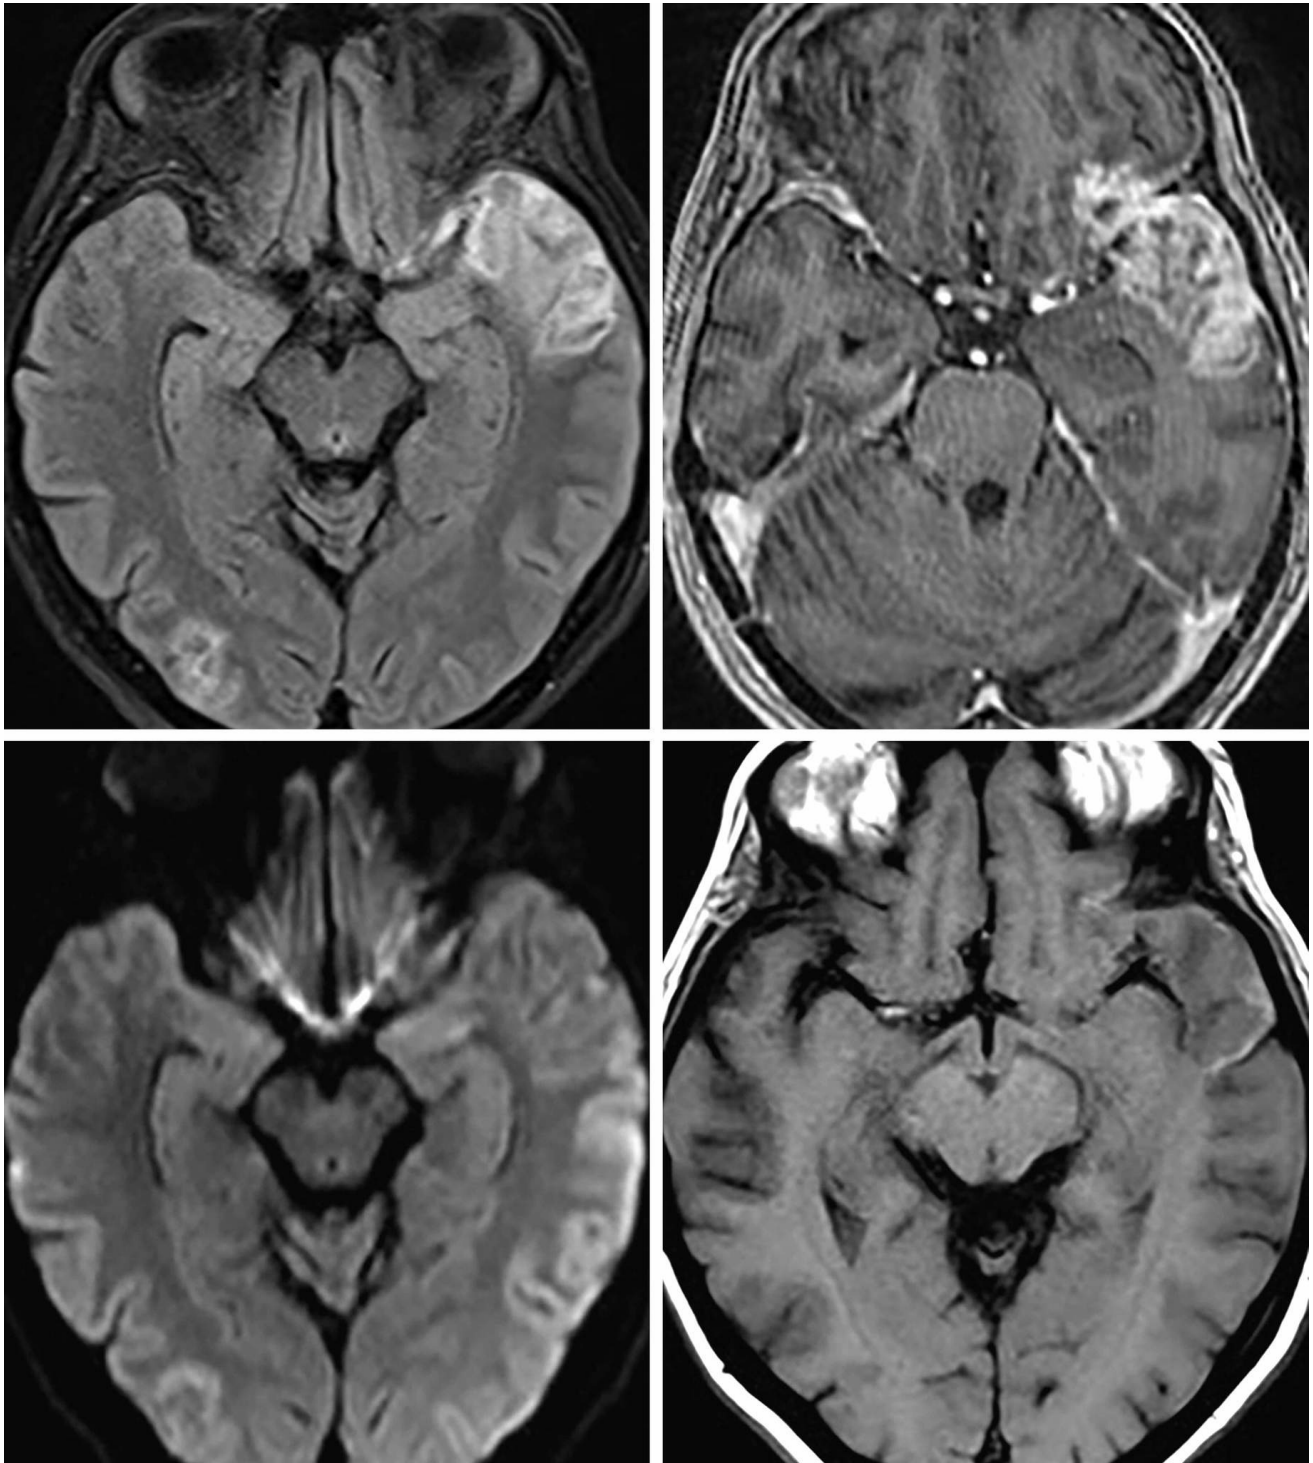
Masslike, cortical, FLAIR-hyperintense signal (top left) with heterogeneous enhancement (top right) in the anterior left temporal lobe and right occipital lobe. (Bottom Left) No evidence of reduced diffusivity
